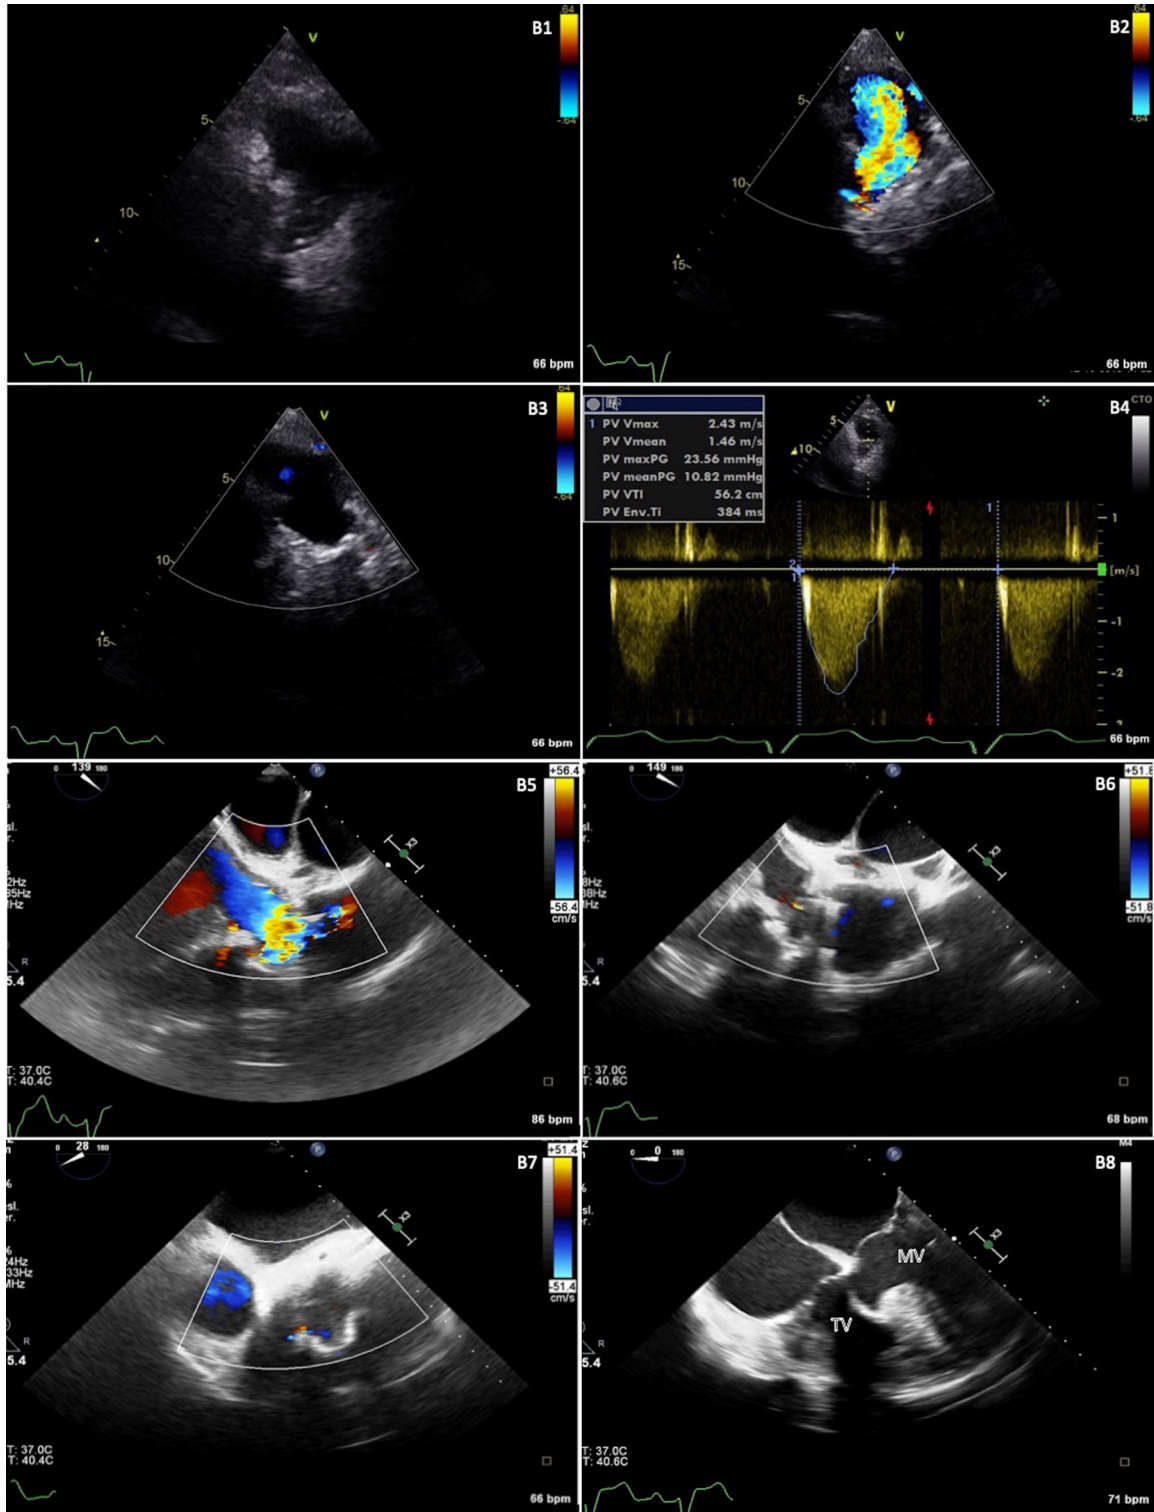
Presents transthoracic echocardiography view of percutaneous pulmonary valve on B1 (set), without signs of vegetations and normal function, with normal flow on systole (B2), just with mild periprosthetic regurgitation on left side of valve, and just a mild regurgitation too through this leak on systole, like was previous(B3) and normal continuous doppler
